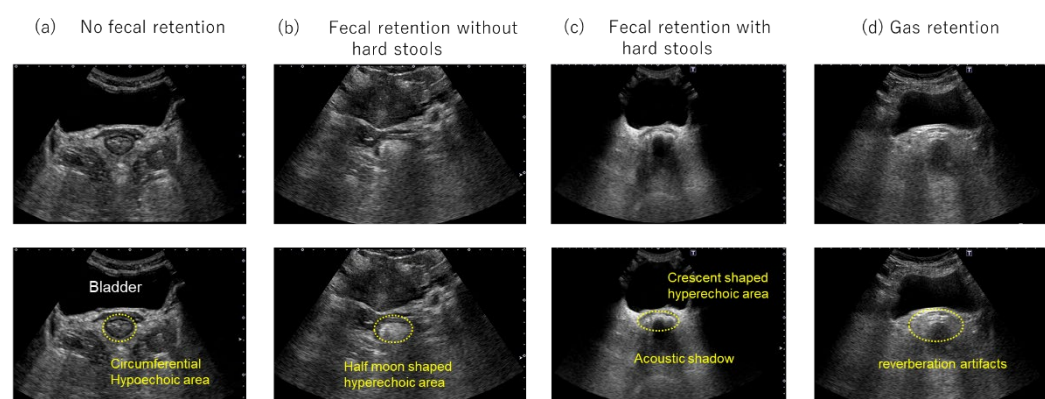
Transverse rectal ultrasound images. (a) No fecal retention, with no hyperechoic area observed. A circumferential hypoechoic area is observed in the lower part of the bladder. (b) Fecal retention without hard stools, revealing a half-moon-shaped hyperechoic area in the lower part of the bladder. (c) Fecal retention with hard stools, revealing a crescent-shaped hyperechoic area with an acoustic shadow in the lower part of the bladder. (d) Gas retention, multiple echoes with reverberation artifacts are observed in the lower part of the bladder.
